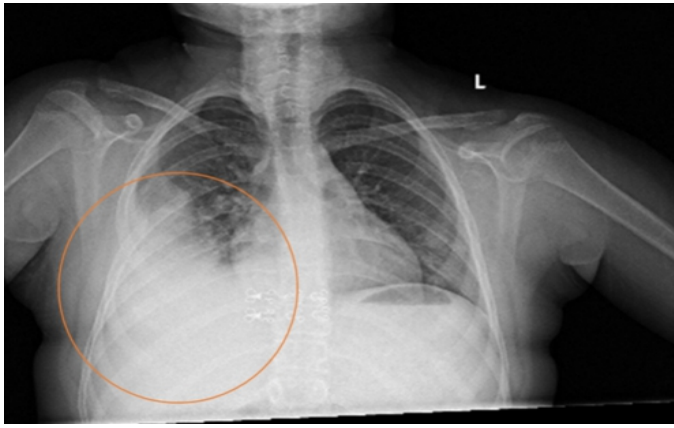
Chest radiograph showing a homogeneous radiopacity in the right lung.
